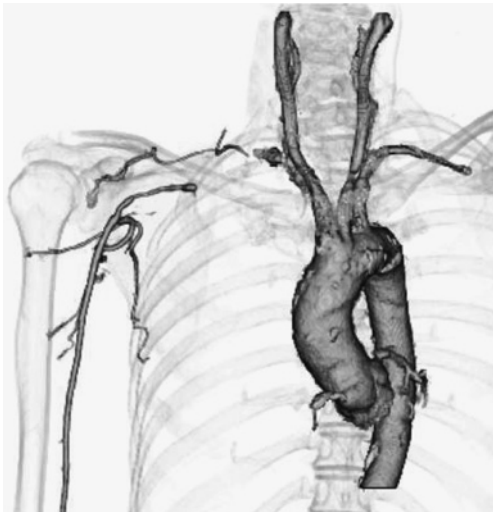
Preoperative three-dimensional computed tomography shows that the artery from the right subclavian artery to the axillary artery was occluded for approximately 5 cm. The wall of the distal artery is irregular.
